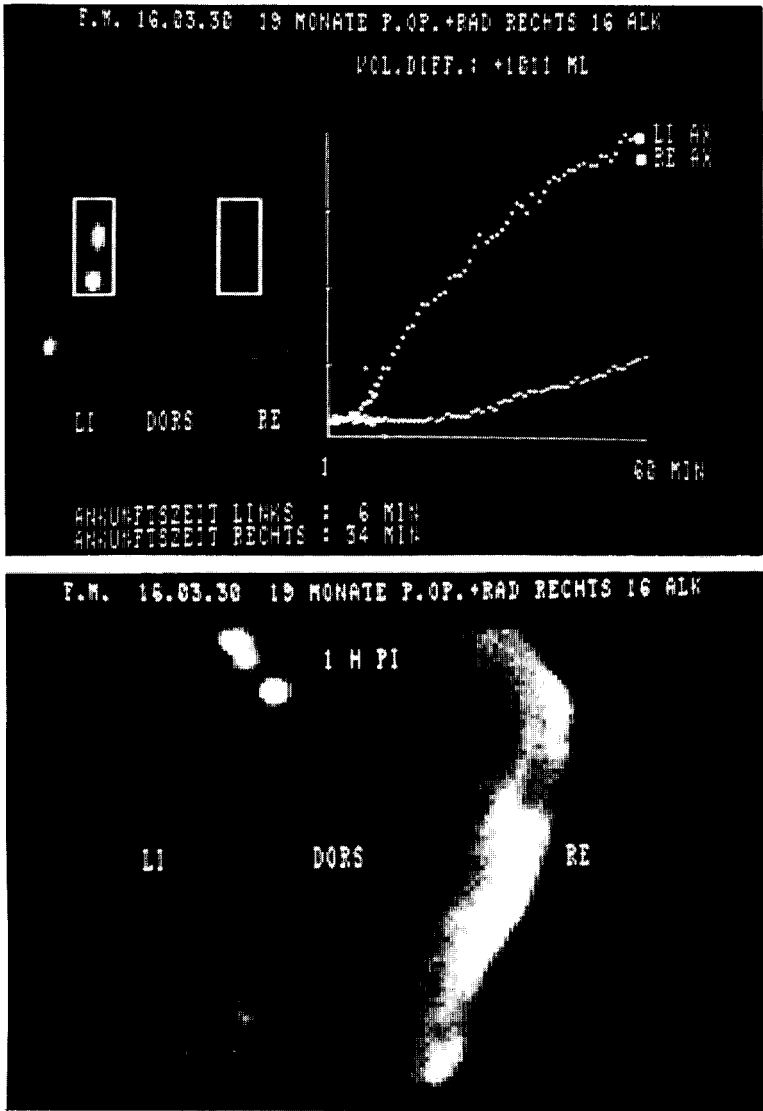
Dynamic and static lymphoscintigram 19 months after modified radical mastectomy and supplemental irradiation. Tracer transport on the right (RE) is further delayed with paucity of axillary nodal uptake (upper); and moreover, there are now large "lymph lakes" with tracer extravasation ("dermal backflow") in the abnormal forearm (below)(compare with Fig. 4).
